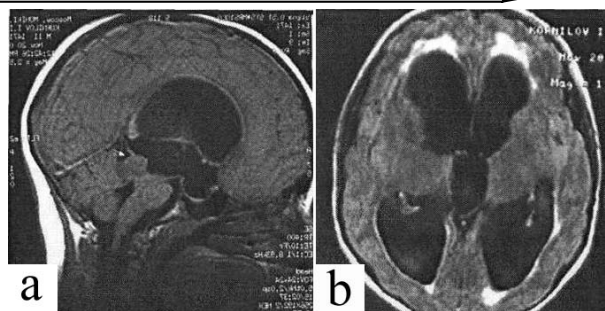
Preoperative CT of the head: a – pineal body tumor with compression of the aqueduct of Sylvius; b – third and lateral ventricles are sharply dilated with marked periventricular edema
